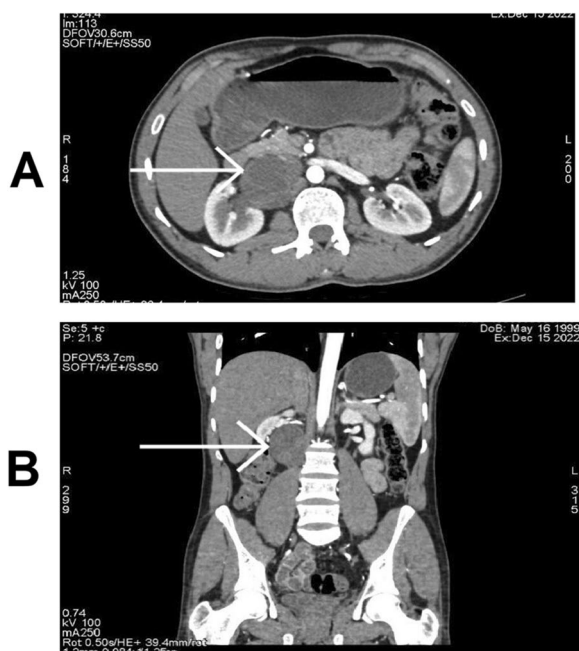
CT scan axial (a) and coronal (b) views demonstrating hypodense cystic area in retroperitoneum on right side abutting duodenum, inferior vena cava, and renal hilum. CT computed tomography
